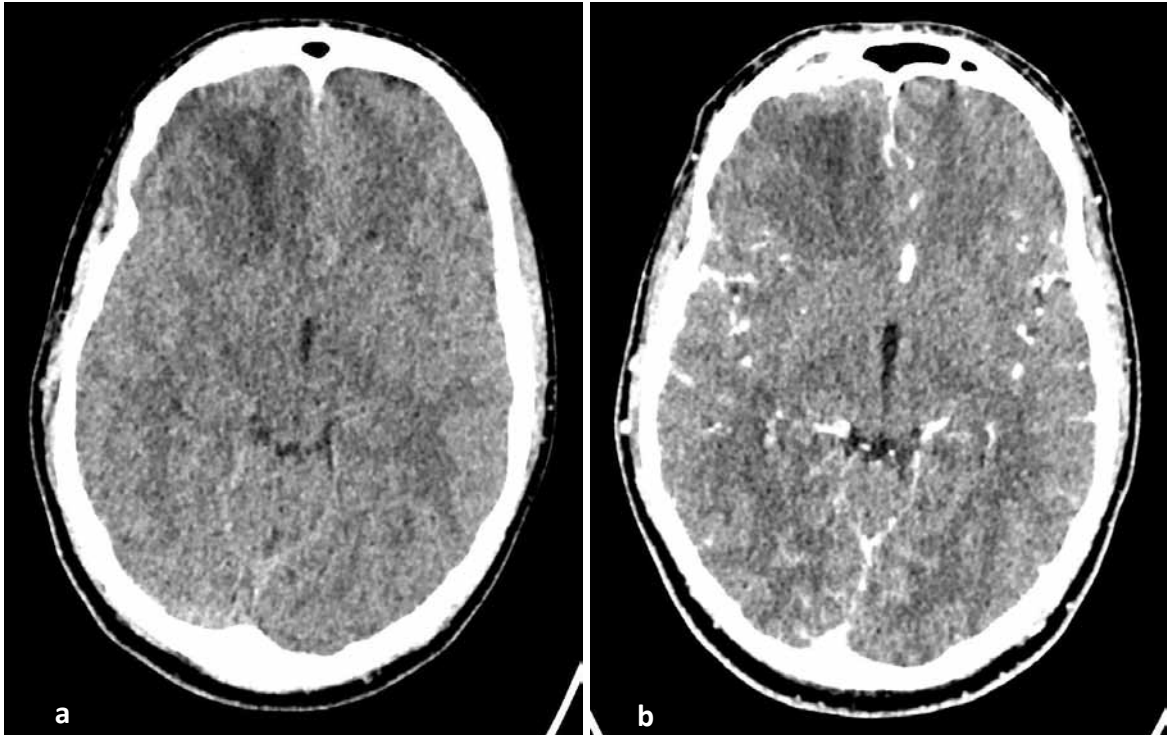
Precontrast (a) and post-contrast (b) brain CT demonstrating an ill-defined right frontal lobe hypodensity, no evident post-contrast enhancement.
